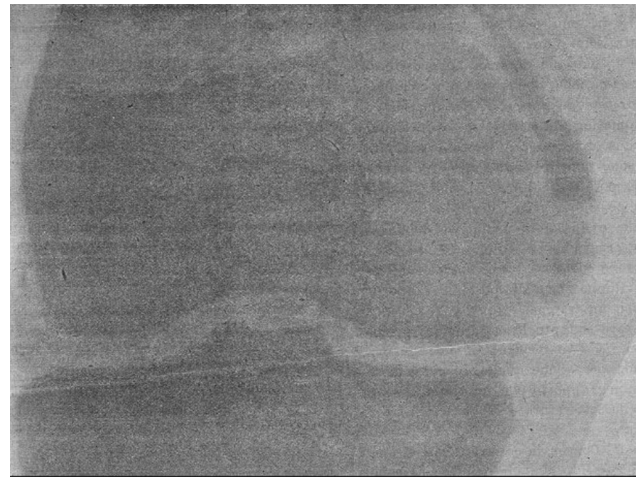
Radiograph from Pellegrini's original publication on ossification of the medial collateral ligament, later designated as Pellegrini-Stieda disease (open license).
